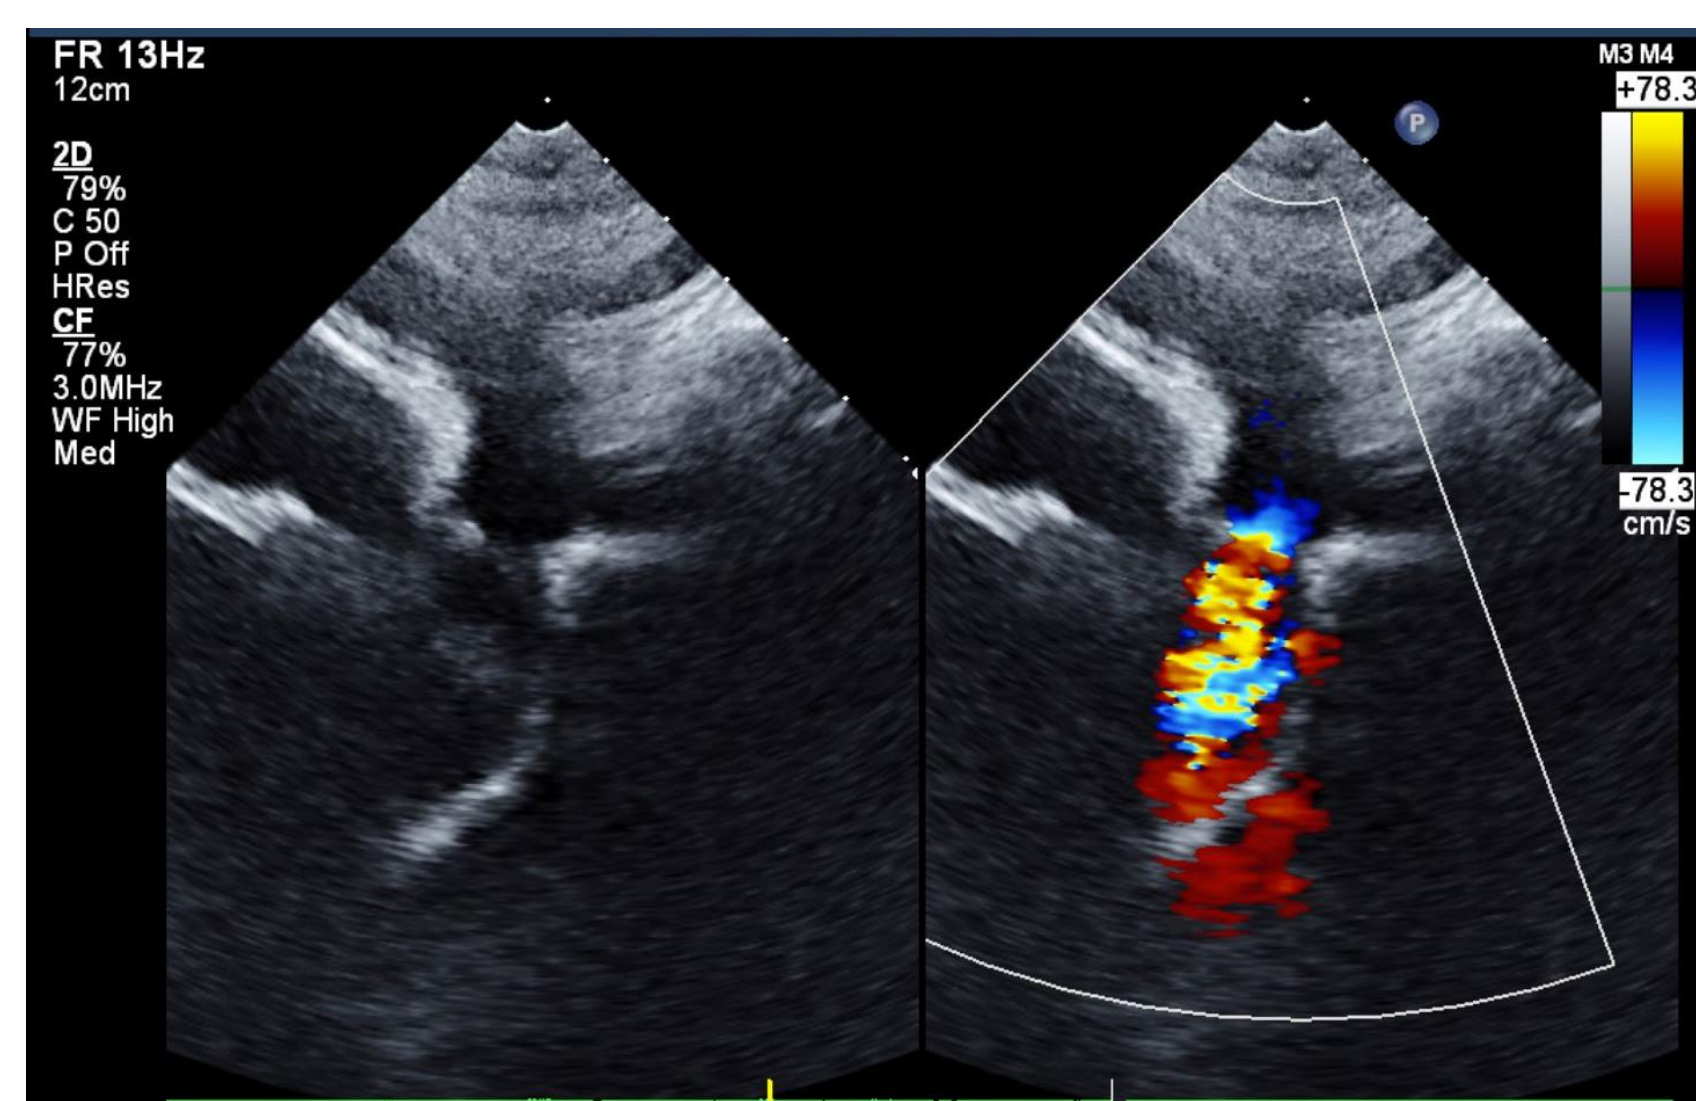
Echocardiogram demonstrating high velocity flow through the aorta.
